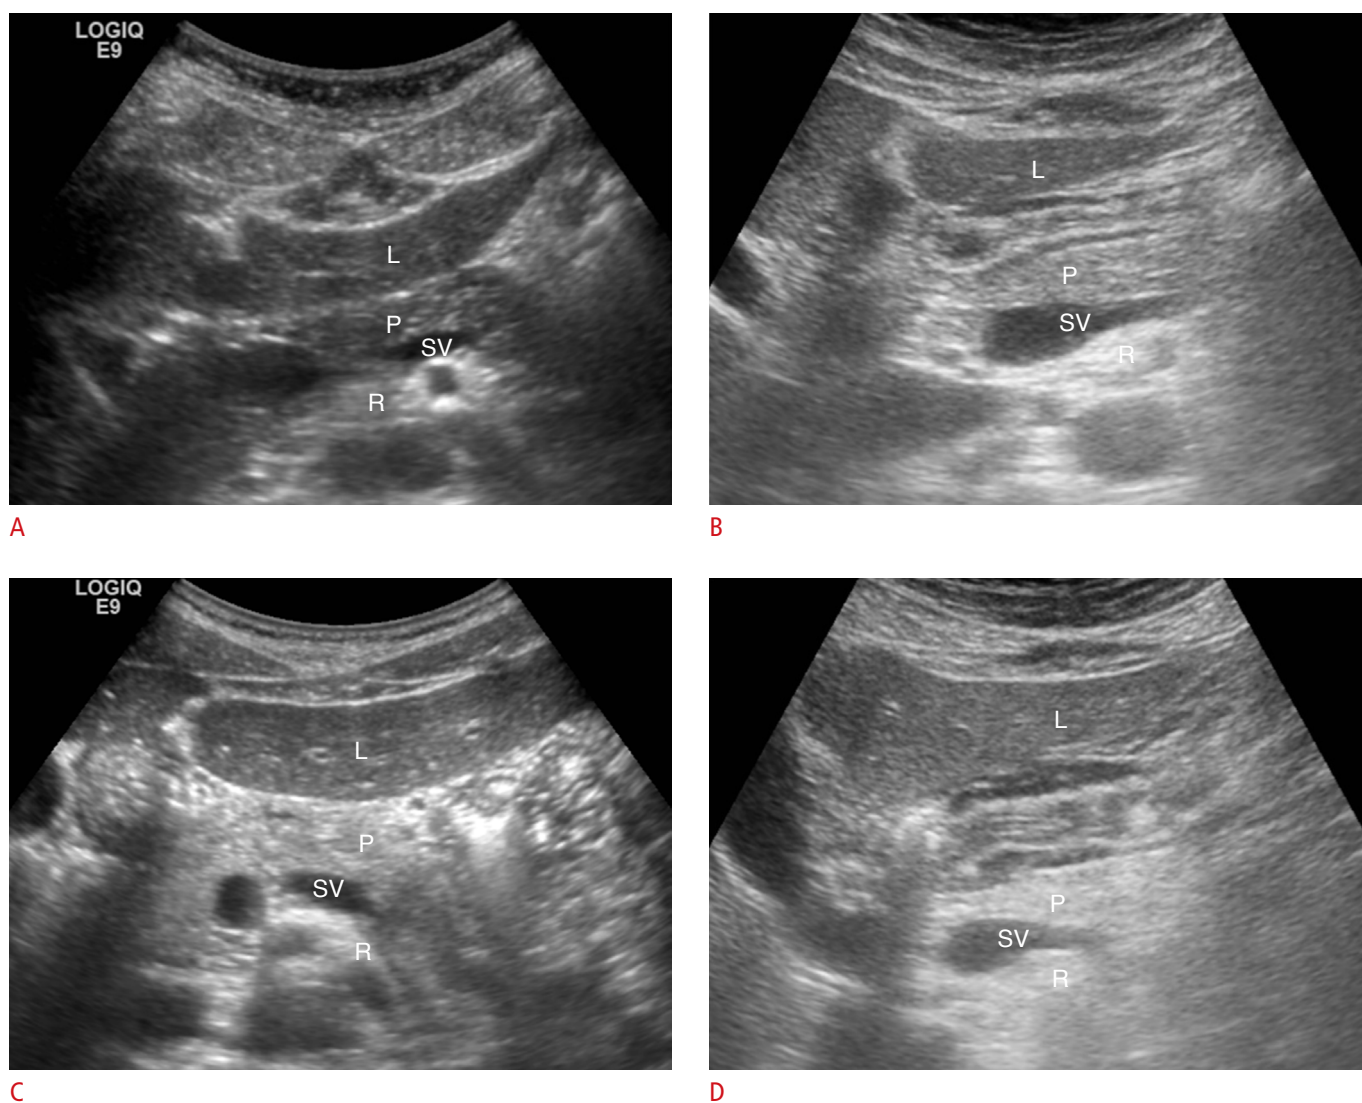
Classification of pancreatic echogenicity on abdominal ultrasound.
